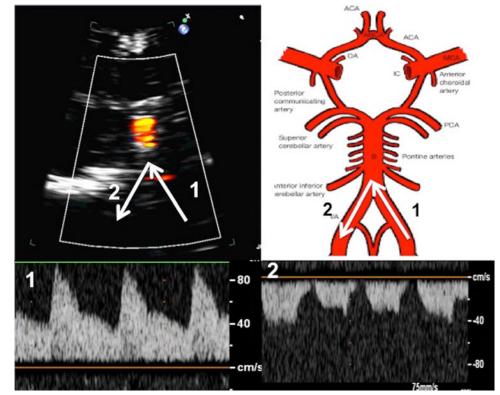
Transcranial ultrasound in coronal plane from anterior fontanelle (*a*) shows the red colour flows towards the transducer in the basilar artery through the left vertebral artery (marked as 1). There was no similar colour flow from the right vertebral artery in the right side (marked as 2). Spectral Doppler with a small sample volume in both the left (1) and right (2) vertebral artery shows characteristic flow reversal in the right vertebral artery which clinches the diagnosis.
